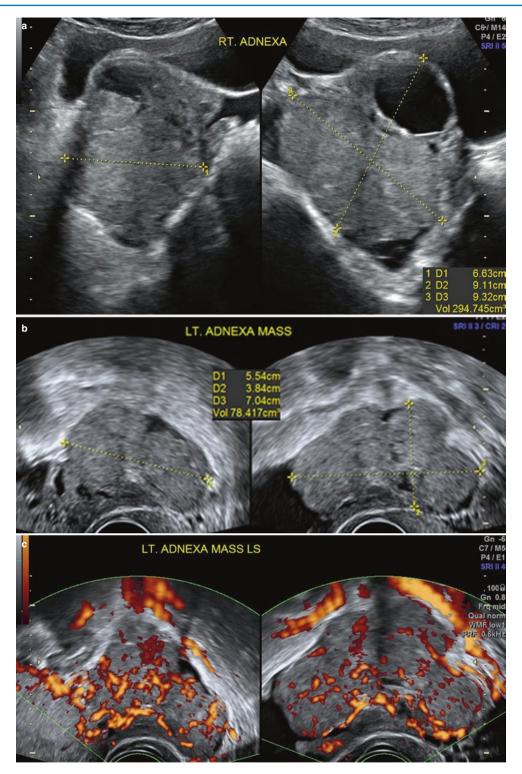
Bilateral high-grade serous cystadenocarcinoma. A 42-year-old woman presented with a complaint of a bloating sensation of the abdomen. CA 125 value was more than 1000 IU/mL. (a) Enlarged right ovary with solid and cystic areas. (b) Left ovary replaced by a solid lobulated mass. (c) Left neoplastic ovary showing high vascularity (colour score 4). (d) The mass showing low-resistance flow (RI 0.24). (e) 3D power Doppler with glass body display showing high and abnormal vascular morphology of the neoplastic mass. (f) Power Doppler showing high vascularity in both ovarian masses. (g) Right ovarian mass showing irregular lobulated external margins (*arrow*) which are well seen because of the surrounding ascitic fluid
